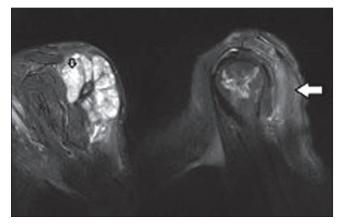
These sagittal T2-weighted images demonstrate high-signal intensity necrotic areas (small arrow) and peritumoral hyperintense edematous regions in the deltoid muscle (large arrow)
